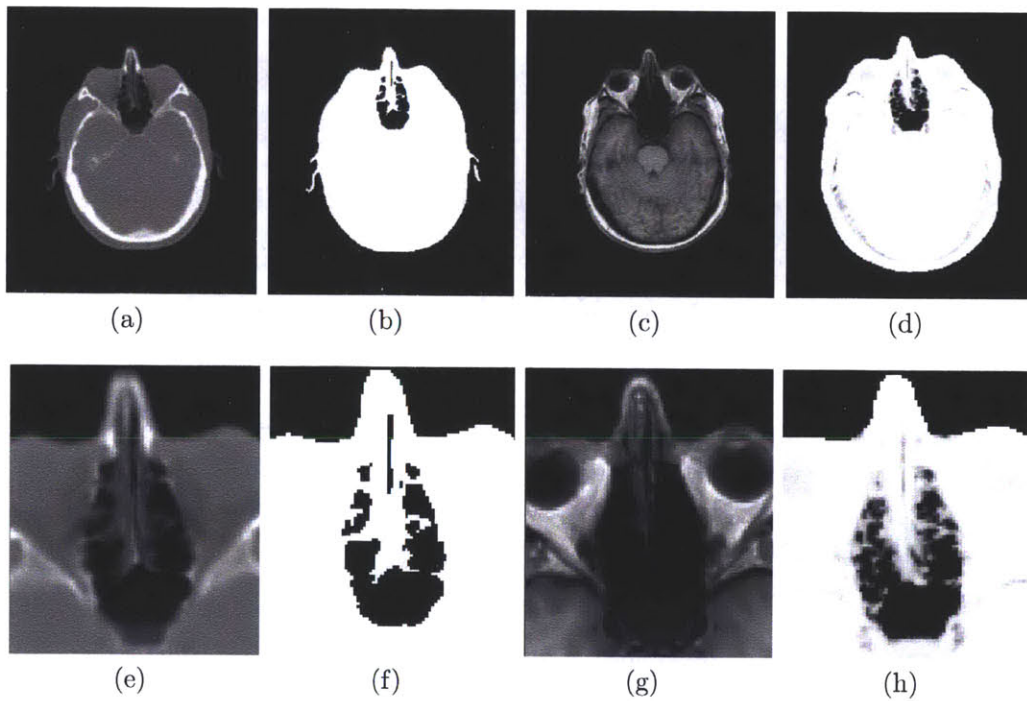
Results of the Classifier. The CT (a,e) is thresholded to produce a tissue/air susceptibility map (b,f) and the T1 (c,g) is segmented using the MR classifier to produce an estimated susceptibility map (d,h). Comparison of the MR-based and CT-based results shows good overall agreement, even in sinus regions where air/bone segmentation is difficult.
